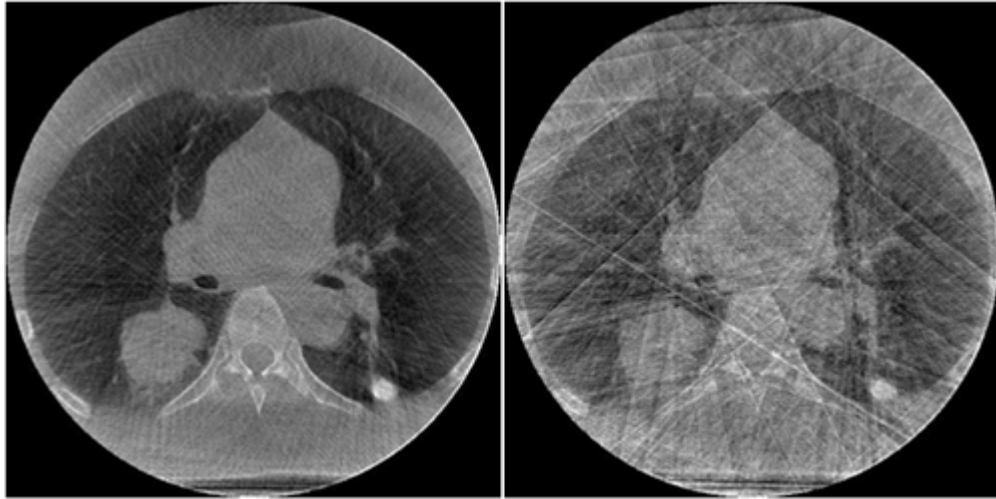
4D-CBCT undersampling artifacts example - Left: Image reconstructed with adequate view angle sampling. Right: image reconstructed after removal of projections. Inadequate view sampling results in streak artifacts.
